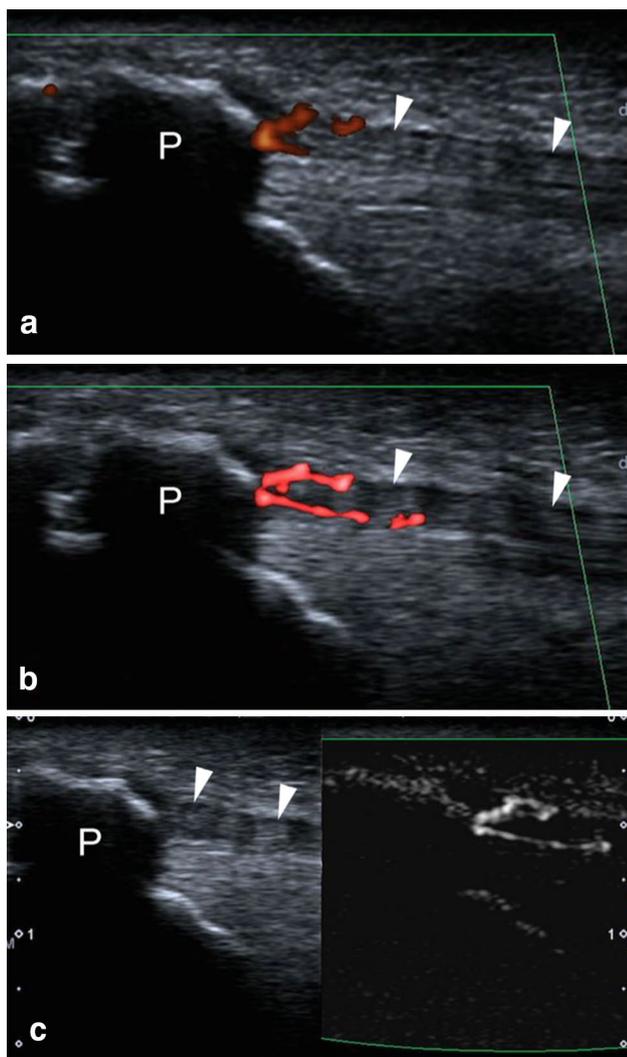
Jumper's knee (patellar tendinopathy). a PD shows hypervascularity of the patellar tendon (arrowheads) at its proximal insertion into the patella (P), b in the same patient, color mode SMI and c monochrome mode SMI show tendon hyperemia, which consists of two linear vascular signals and is more conspicuous than vascularity detected using conventional Doppler imaging. Color mode SMI and monochrome mode SMI carry the same information
